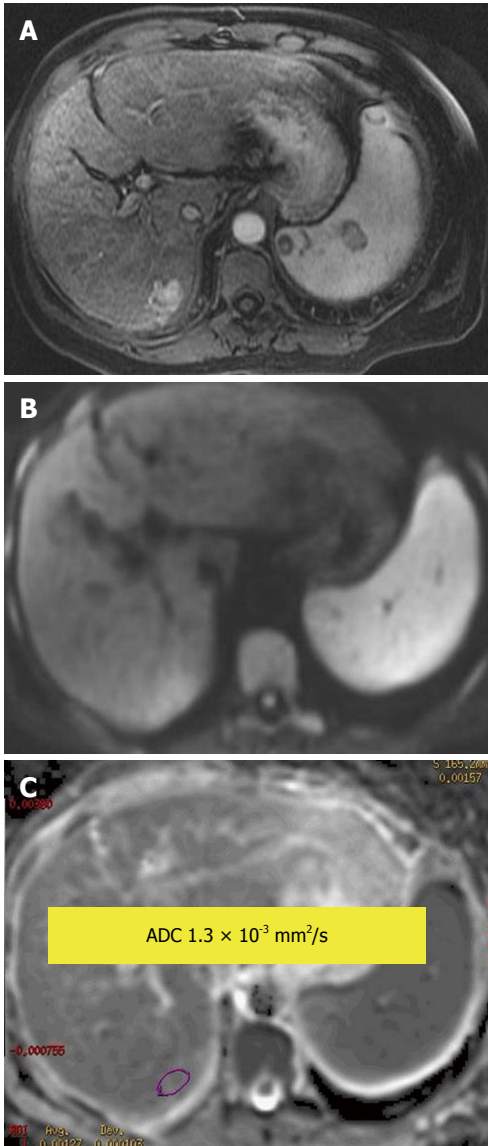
Hepatocellular carcinoma. A: Enhanced arterial phase T1-weighted gradient recalled-echo; B: Diffusion-weighted image; C: Apparent diffusion coefficient (ADC) map. An arterial enhancing lesion with impeded diffusion and ADC = $1.3 \times 10^{-3} \text{ mm}^2/\text{s}$ is visible.
